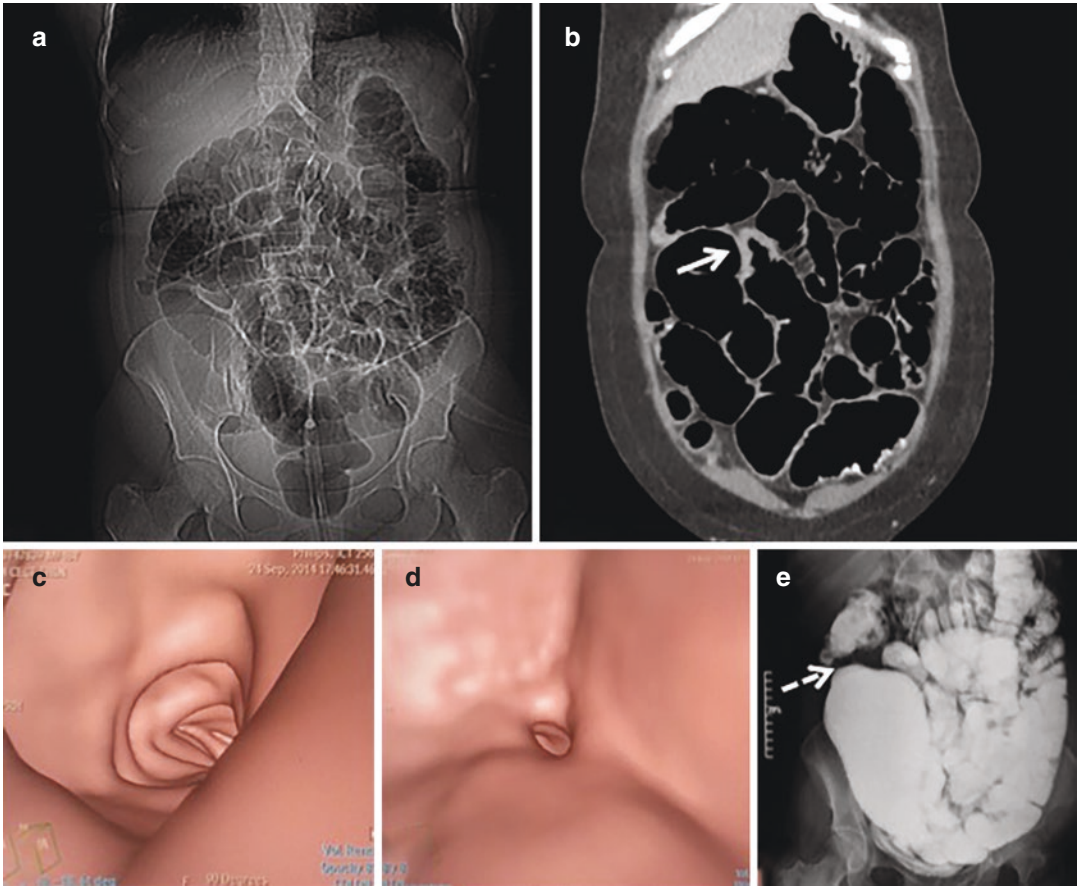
30-year-old woman who presented with subacute episodes of intestinal obstruction. CT virtual enteroscopy was performed. (a) CT scanogram shows the small and large bowel distended with carbon dioxide. (b) Coronal contrast-enhanced CT image shows circumferential mural thickening with hyperenhancement of one of the ileal
